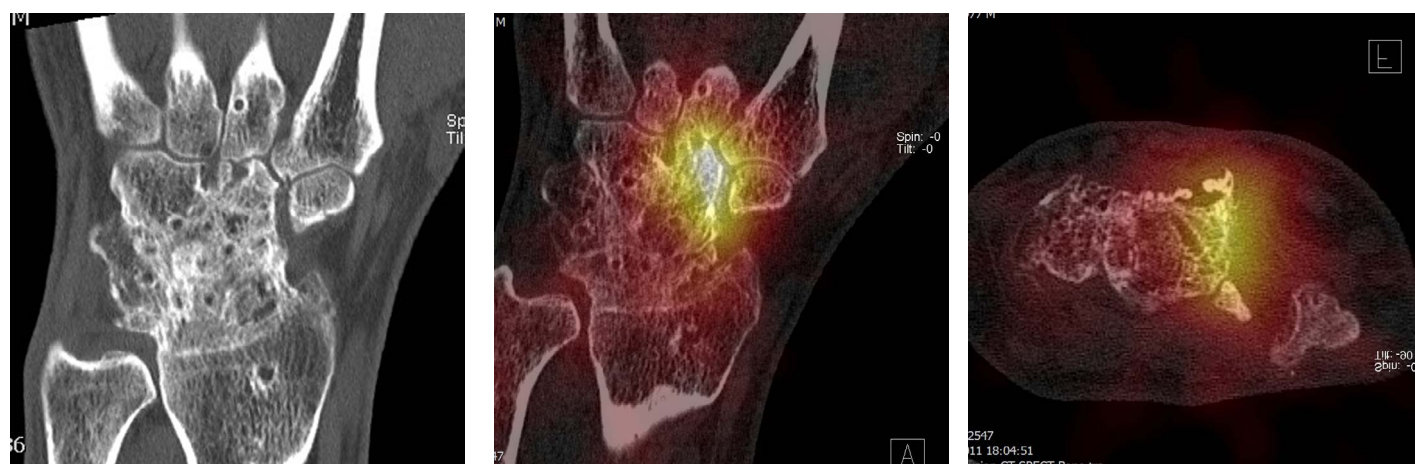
Images of a 36 year old man with a history of multiple surgical procedures of the right hand due to an initial fracture of the scaphoid with subsequent non-union and persistent pain despite resection of the scaphoid and four-corner arthrodesis. A. CT demonstrated multiple postoperative and degenerative alterations in this complex anatomical situation. B and C. SPECT/CT showed a metabolically active osteophyte originating from the capitate that made contact with the extensor tendons and apparently caused an inflammatory reaction of the surrounding soft tissue. Following the diagnostic work-up, the osteophyte was removed in a very limited surgical procedure resulting in a good subjective outcome.
